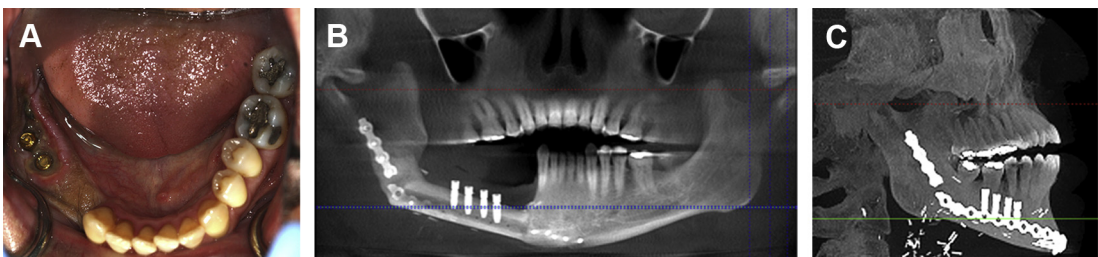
(A) Mandibular defect reconstructed with fibular reconstruction. Intraoral view. Owing to the soft tissue approximation at the surgery, 2 dental implants were used to support the prosthesis. (B). Cone beam computed tomography panoramic view. (C) Cone beam computed tomography lateral view.
